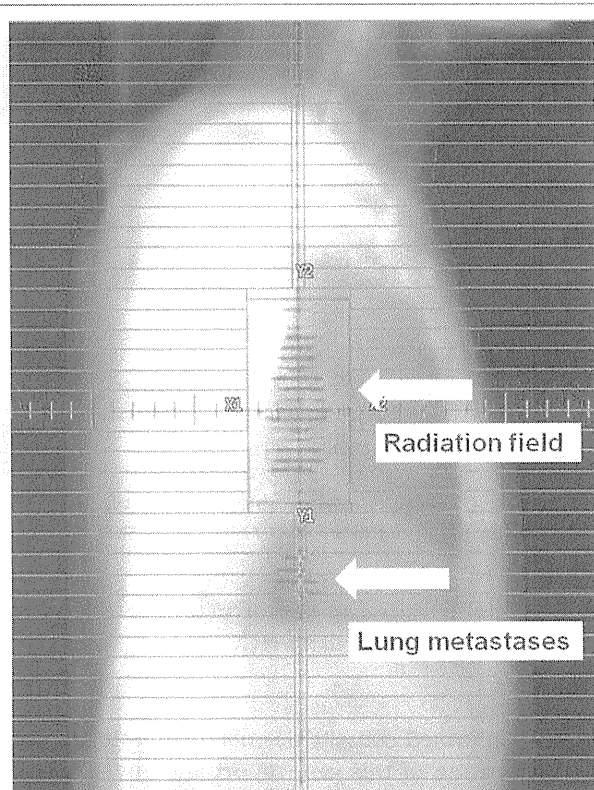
Chest CT image showing the radiation dose distribution: sagittal view.
